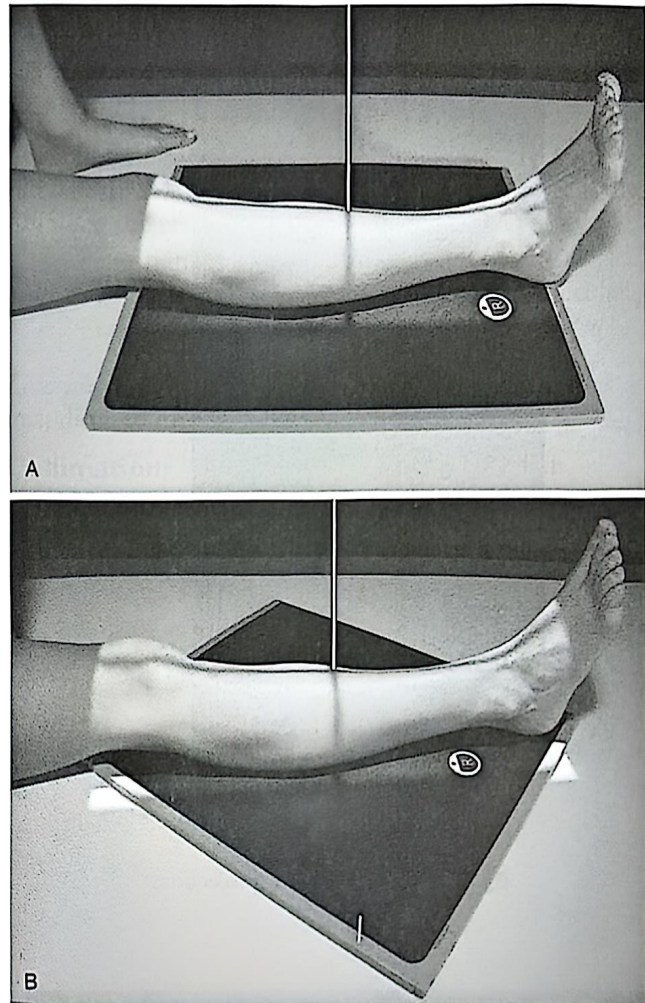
Lower leg. Position for AP projection. (A) Usual orientation of IR. (B) Diagonal placement of IR, when lower leg is too long to fit within the long dimension of the IR. Exposure field must include entire corners of a computed radiography imaging plate to ensure good image quality.
